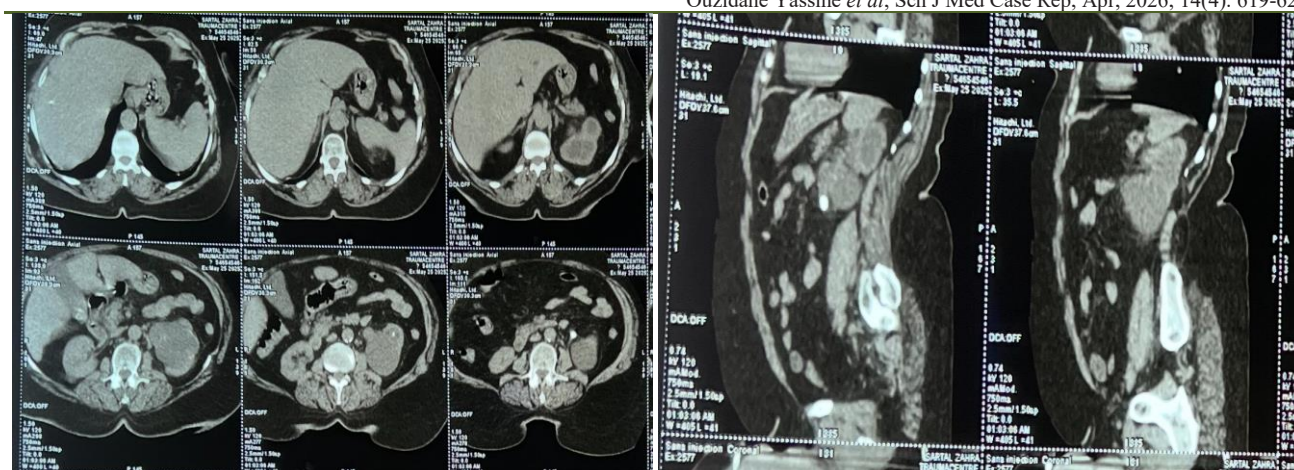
CT scan showing ureterohydronephrosis due to a left lumbar stone
